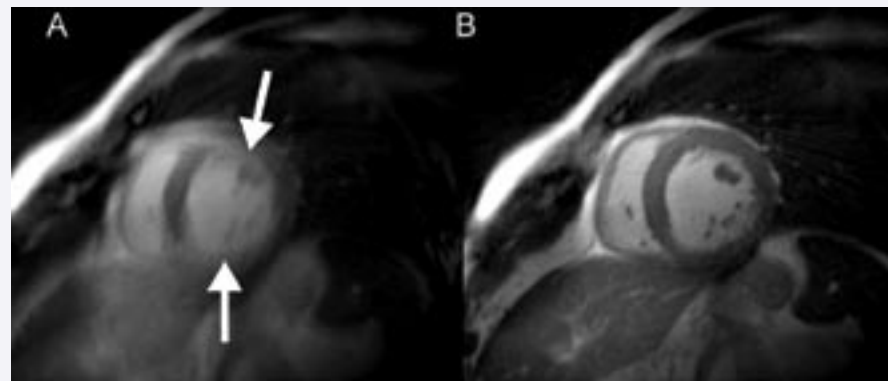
Cardiac MRI images (short-axis orientation) acquired during a free-breathing patient study. Image (A) was acquired using four signal averages. Image (B) was acquired using respiratory self-gating. Notice the motion artifacts and blurring in (A), see arrows, clearly mitigated by self-gating in (B).
